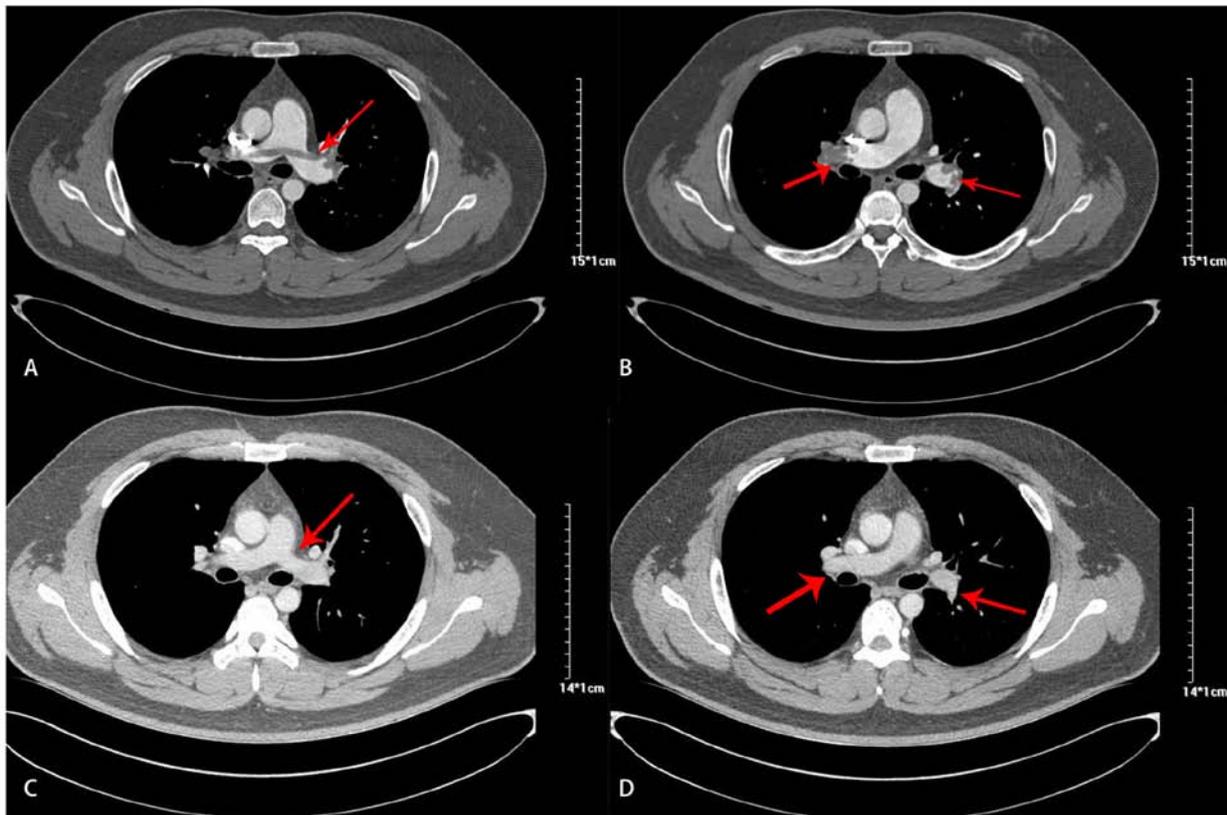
Results of computed tomography pulmonary angiography before rivaroxaban treatment and after 90 days of rivaroxaban treatment. (A and B) CTPA was performed to confirm diagnosis and showed intraluminal filling defects representing thromboses in the bilateral pulmonary artery trunk and branches; (C and D) Follow-up CTPA was normal after 90 days on rivaroxaban. CTPA, Computed tomography pulmonary angiography (indicated by red arrows).
